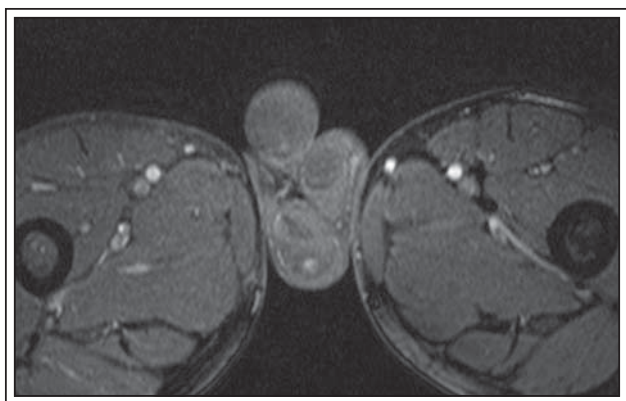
Testicular MRI showing wedge shaped areas of decreased enhancement in bilateral testicles representing areas of infarction.
